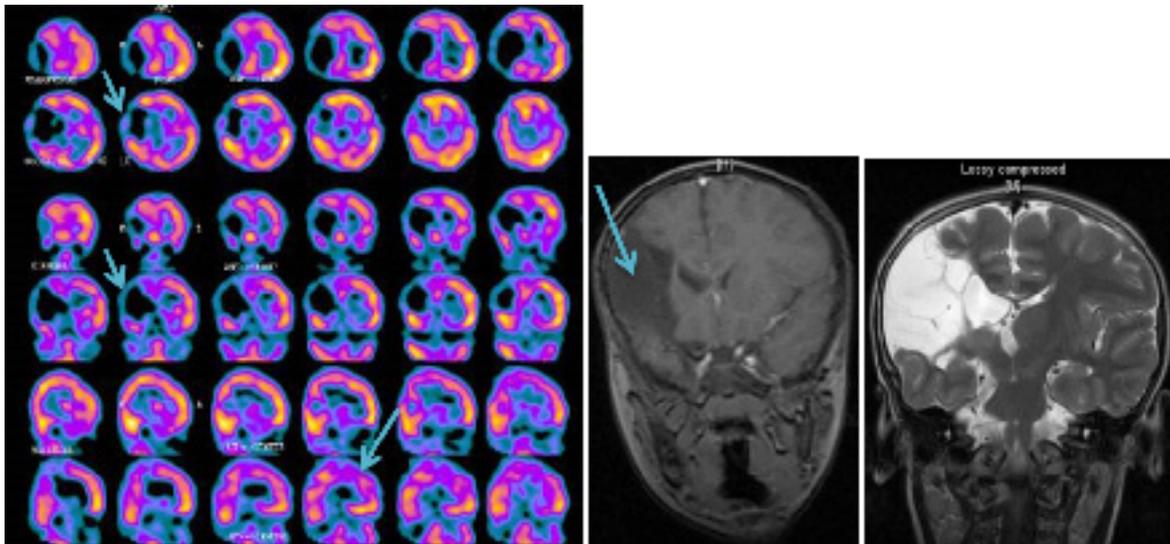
A 10 years old boy with left sided hemiplegia. Developmental delay and seizure. SPECT: Large perfusion defect (arrow) involving great part of right cerebral hemisphere (fronto parietal, parieto occipital and parietal lobes) matching with MRI changes.
